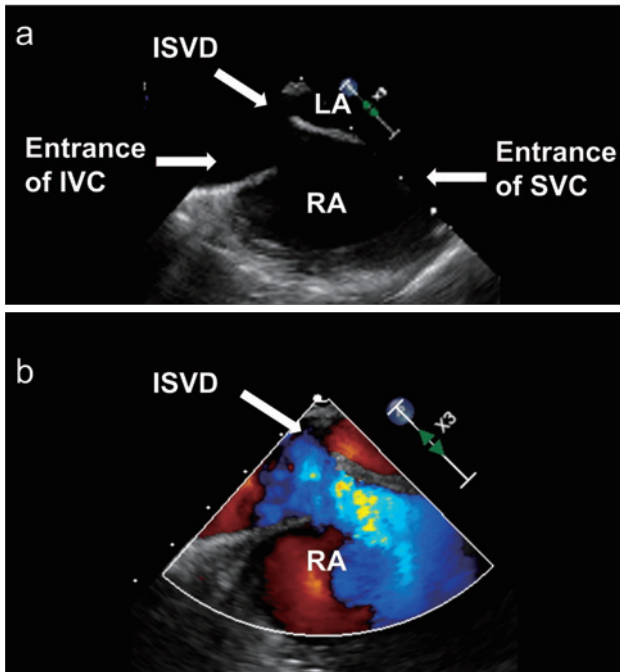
a: Plain echocardiogram, b: Color Doppler transesophageal echocardiogram at the level of the atrial septum revealed the recurrent defect near the entrance of IVC. No residual atrial septum is seen inferiorly. SVC: superior vena cava, IVC: inferior vena cava, ISVD: inferior sinus venous defect, LA: left atrium, RA: right atrium.
